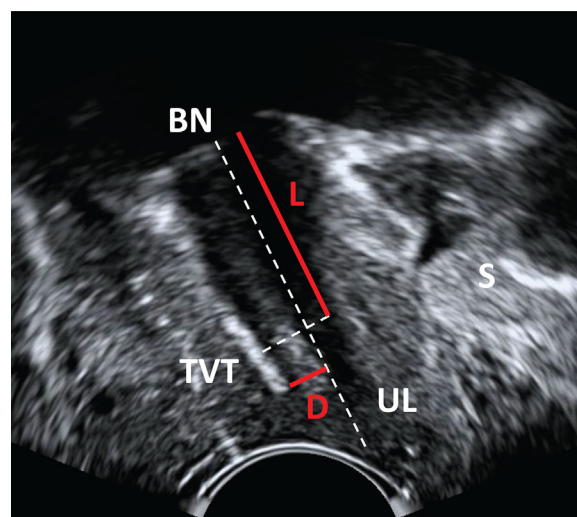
Tape localization by pelvic floor sonography with a transvaginal probe. Sagittal view. BN, bladder neck; D, minimal tape-urethra distance (mm), from the closest position of the tape to the echolucent part of the urethra, consisting of mucosa, submucosa, and smooth muscle layers (longitudinal smooth muscle-complex);⁶ L, urethral length from projected mid-tape position to bladder neck (mm); S, symphysis pubis; TVT, tension-free vaginal tape; UL, urethral length (mm) ($L/UL \times 100$: relative tape position [%])
